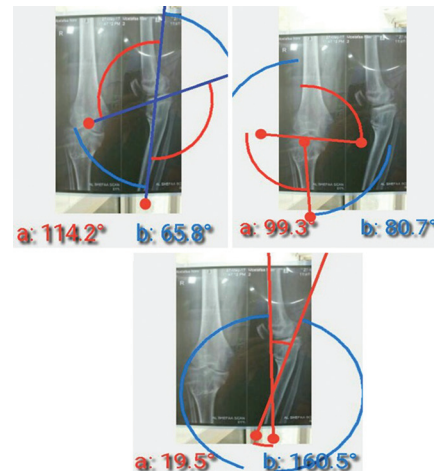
Preoperative radiography with different angles for deformity.
